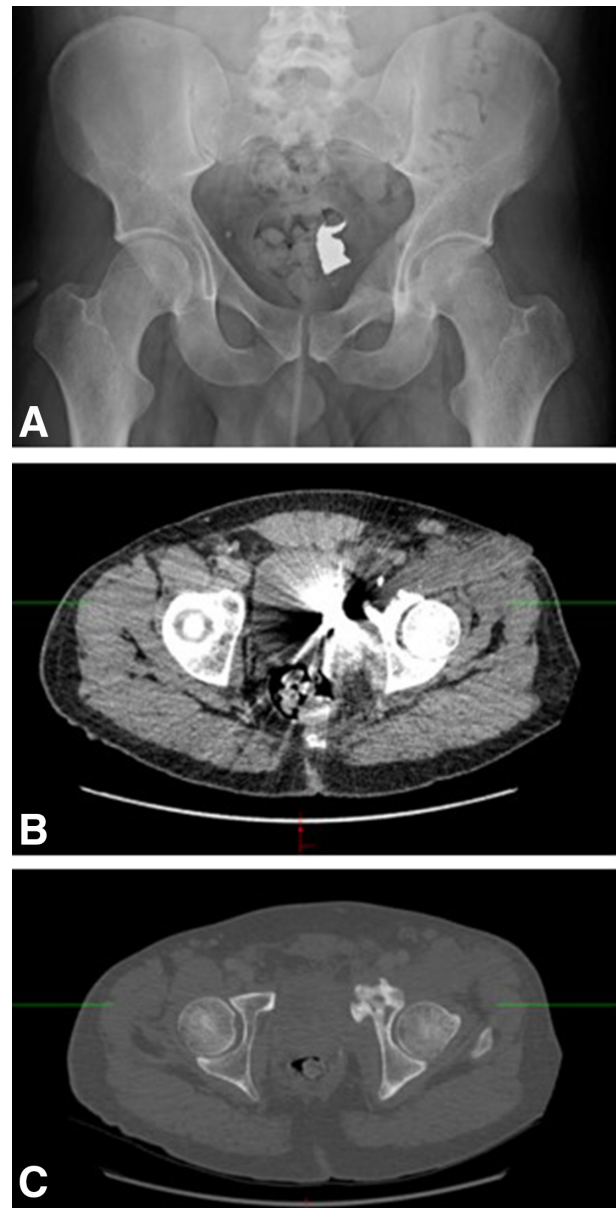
X-ray (A) and CT of the pelvis revealed a 2.3×1.4×4.5 cm foreign body abutting the urinary bladder (B) with adjacent cortical margin irregularity of the acetabulum and left superior pubic ramus (C) concerning for osteomyelitis.
